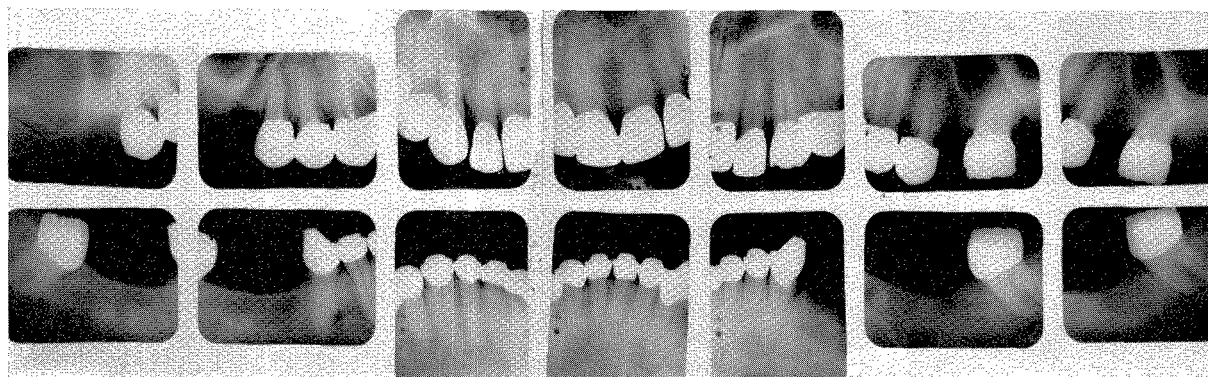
Roentgenograms taken in March, 1954.
